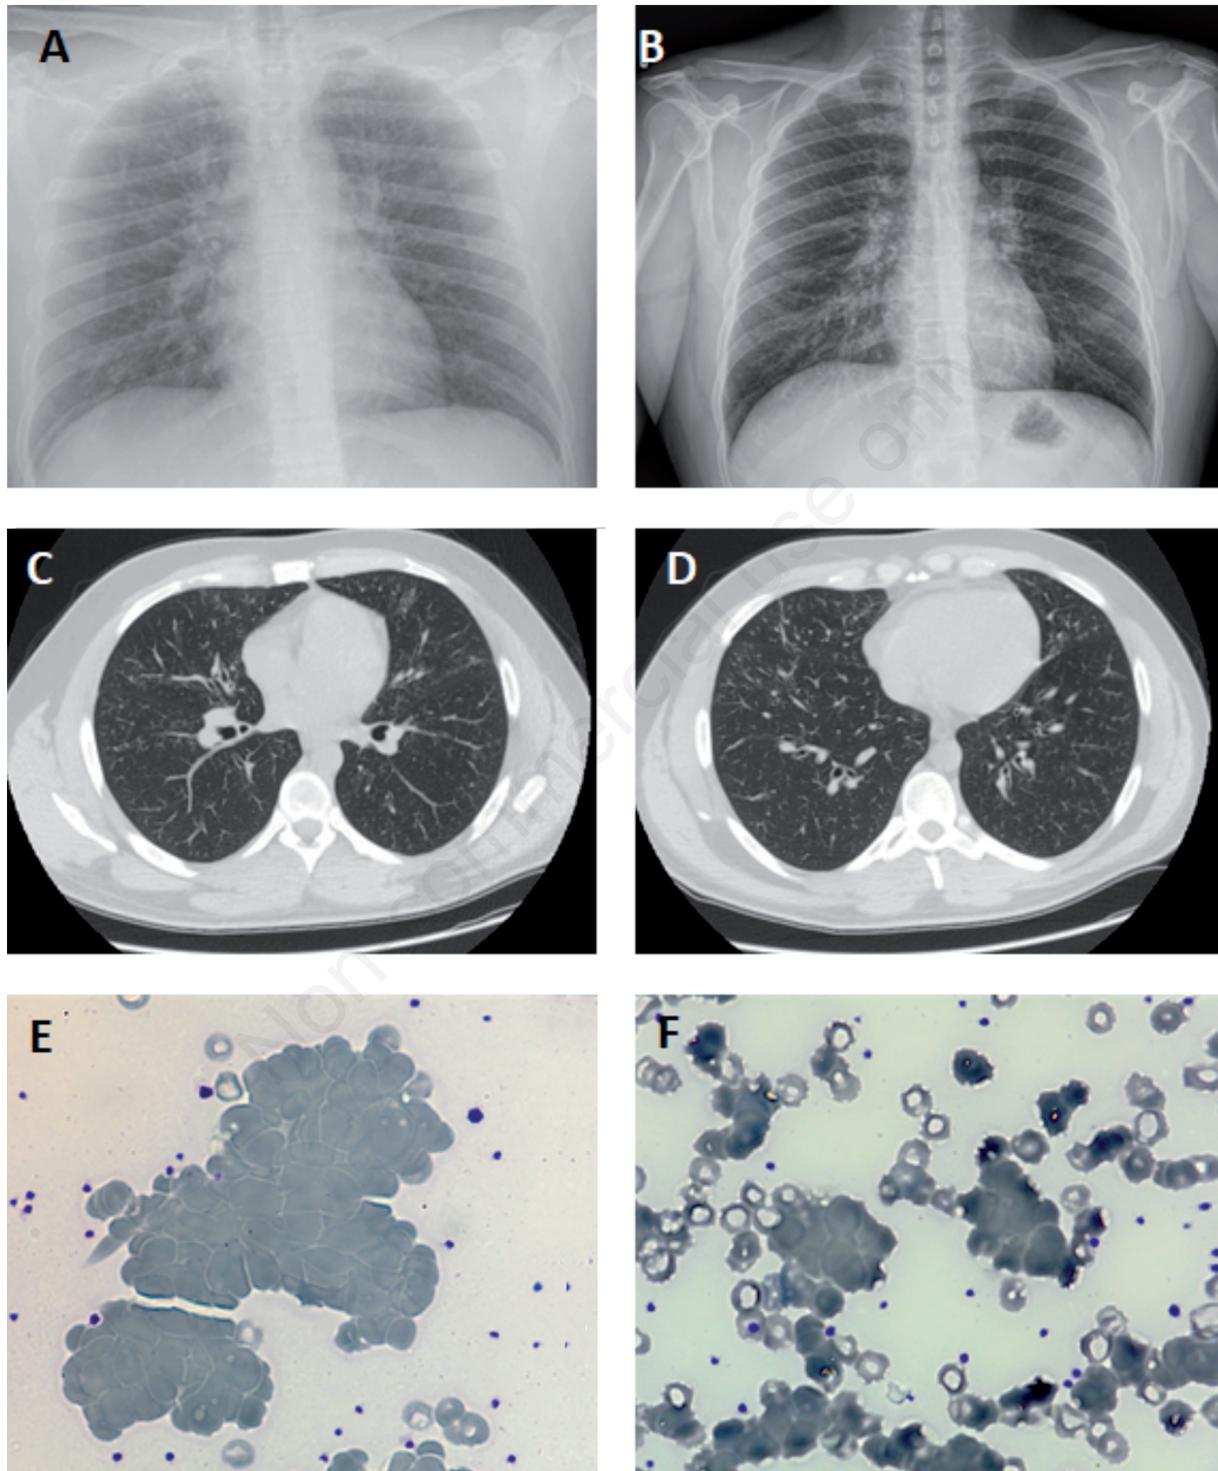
Chest X-ray of the patient. A) Small opacity in right upper lung and large dense opacity in the left lung on day 4 after onset. B) Chest X-ray after therapy with clear lung field on day 27. C and D) Computed tomography scan showed Bilateral opacities progressed with left lung consolidation on day 7. E and F) Blood smear showed red cell agglutination. E: 4°C image of blood smear showed agglutination of red blood cells (RBC); and F) at 37°C showed normal distribution of RBCs.
